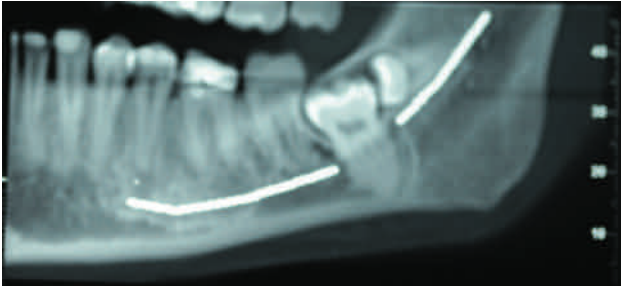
Panoramic slice on CBCT. Note the presence of the left lower distomolar and the third molar in relation to the inferior dental nerve.
